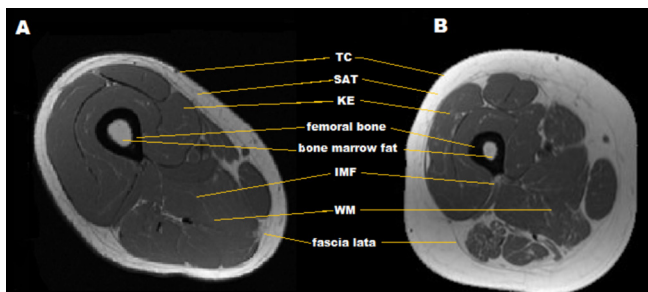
T1-weighted thigh magnetic resonance imaging (MRI). (A) T1-weighted MRI of thigh in SCI individual with lower SAT and skeletal muscle atrophy. (B) T1-weighted MRI of thigh in person with SCI showing extensive skeletal muscle atrophy, SAT and IMF infiltration. TC: Thigh circumference; SAT: subcutaneous adipose tissue; WM: whole muscle; KE: knee extensor; IMF: intramuscular fat.
